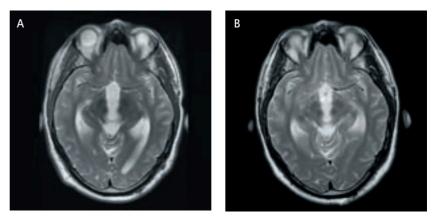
Axial T2-weighted MRI scans prior to (A) and after (B) ETV. The signal void in the anterior third ventricle indicates a patent stoma.
